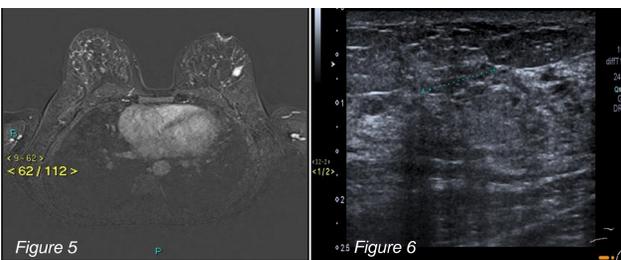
T1 subtracted post-contrast sequence shows avidly enhancing mass corresponding to the site of CT abnormality.
